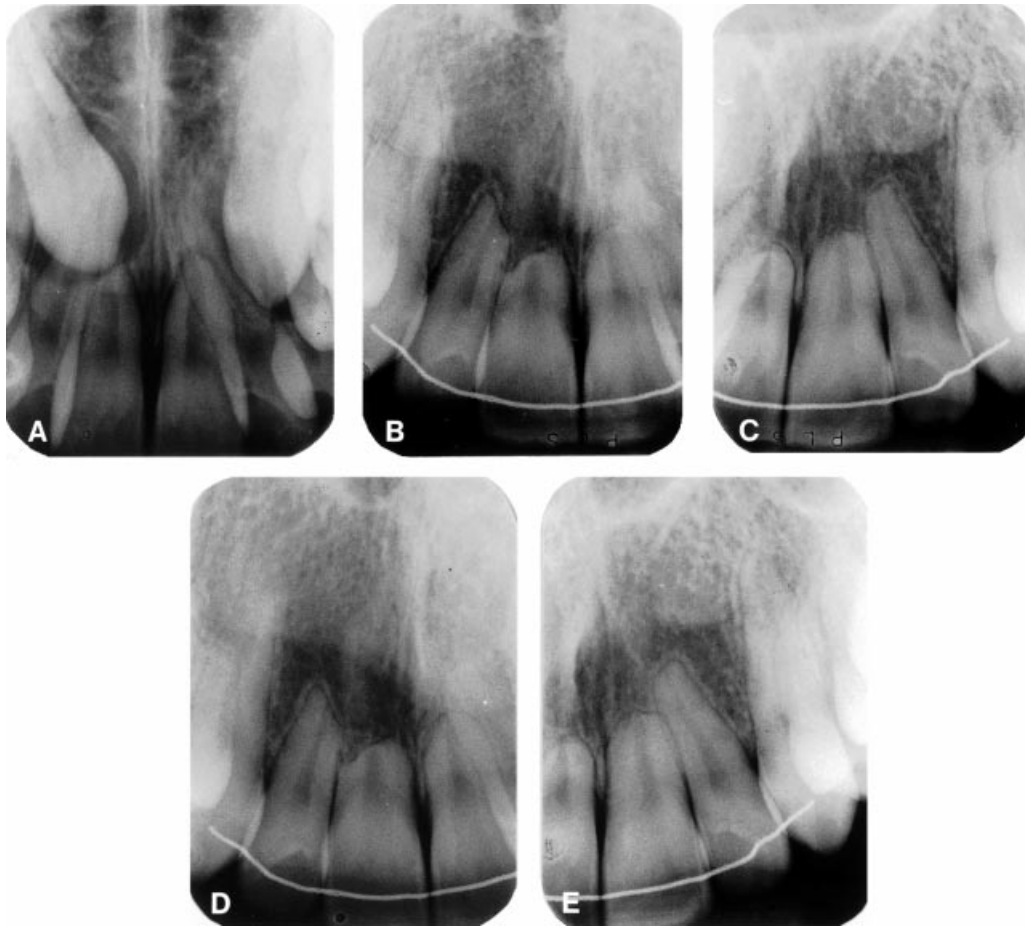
Radiographs of a patient, aged 21 years, with severe apical root resorption. Follow-up period 7 years. Twistflex retainer 13–23. (A) Before treatment. (B,C) After treatment. Severe apical root resorption of all maxillary incisors. (D,E) At the follow-up control. Total root length 12, 21, 22 >9 mm; 11 <9 mm. Increased mobility in 11. Periotest values 12 = 1; 11 = 10; 21 = 5; 22 = -3.
